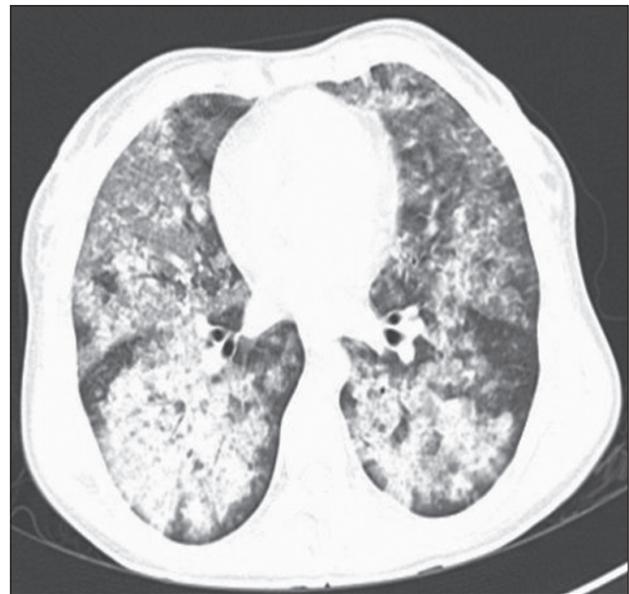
Computed tomography scan chest (plain) showing diffuse multifocal patchy areas of consolidation and ground glassing in both lungs
